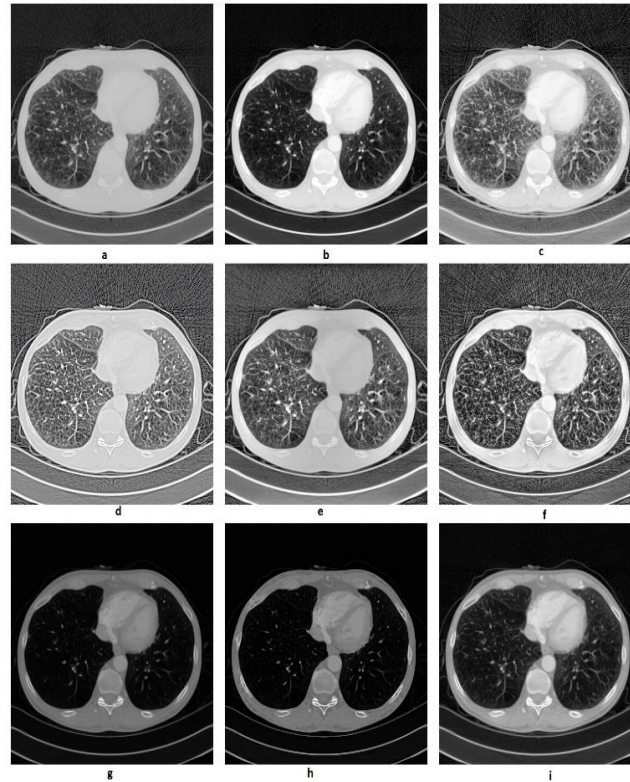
Enhanced test CT image of Lungs1 by a) Reinhard (b) Kim (c) Khan (d) Li (e) Liang (f) Shibata (g) Al-Ameen (h) Gandhamal (i) Proposed, in the reading order.
